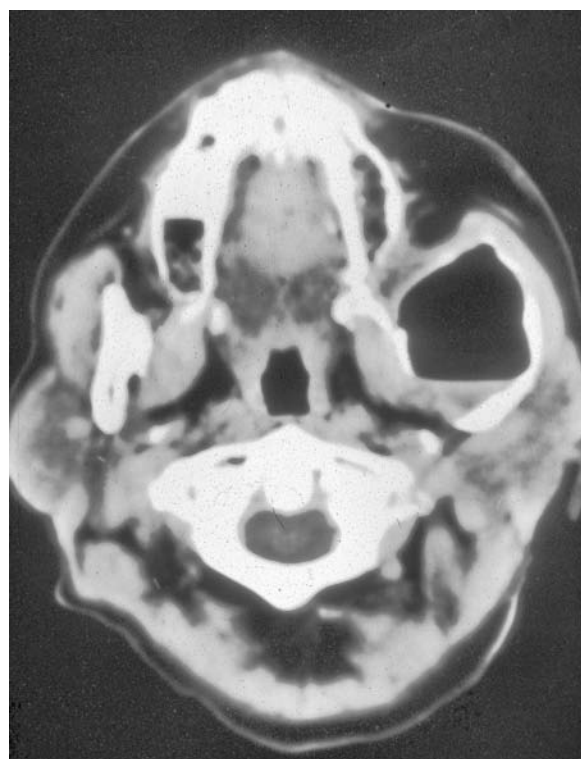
Axial CT scan showing an odontogenic keratocyst in the left ascending ramus of the mandible. There is buccal and lingual expansion and thinning of the cortical plate which is breached on the lingual aspect. (Courtesy of Professor J. Lownie.)
